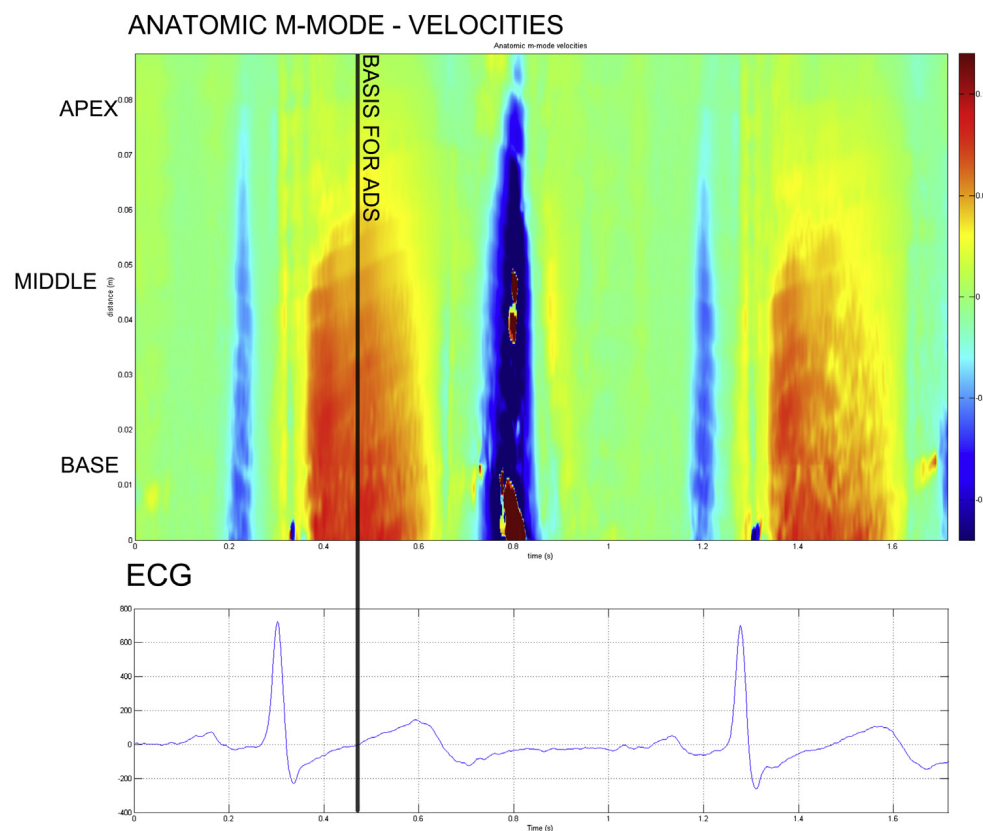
Curved anatomic M-mode ultrahigh-frame-rate tissue Doppler imaging velocity data from the ventricular septum in a healthy volunteer. The midsystole is selected as basis for the anatomic Doppler spectrum. The scale for the color map is in meters per second.
